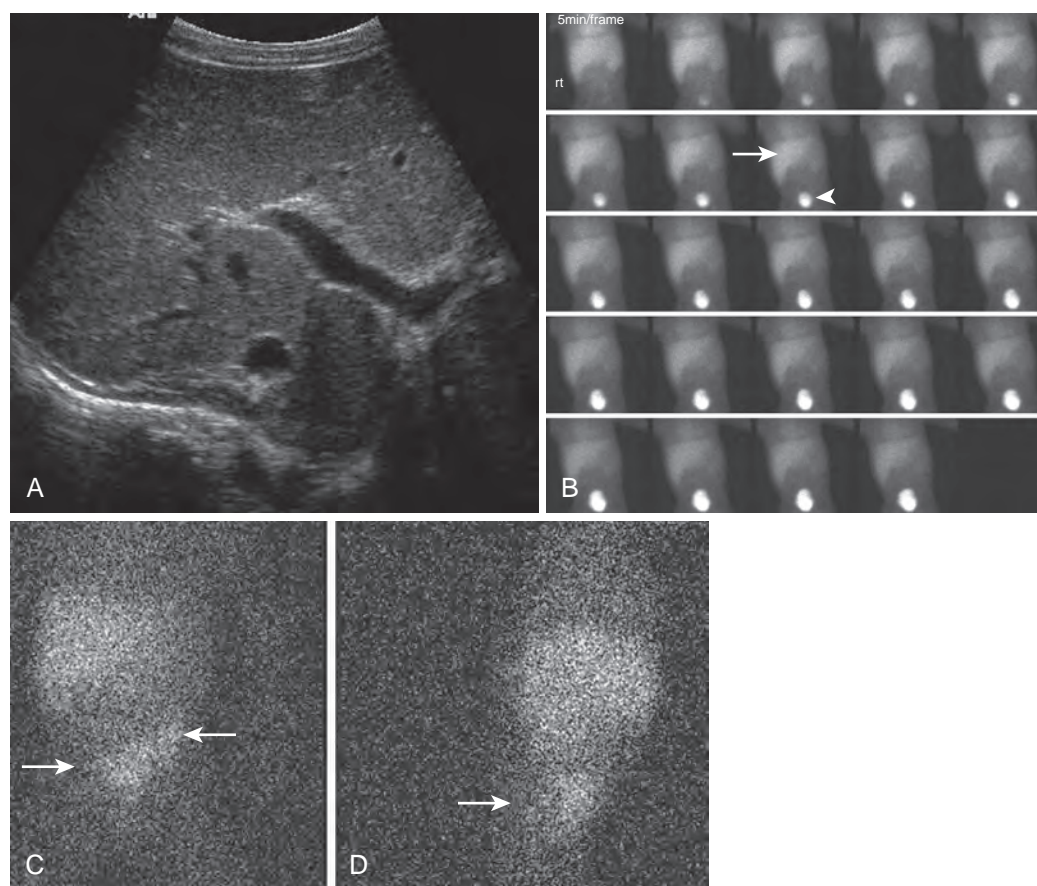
Nonsyndromic intrahepatic bile duct paucity: ultrasound and hepatobiliary scintigram. A. The cholestatic infant has a lack of sonographically identifiable gallbladder or intrahepatic bile ducts. B. Nuclear scintigraphy demonstrates poor hepatic extraction (arrows) of the radiopharmaceutical. Some radiopharmaceutical is seen in the urinary bladder (arrowhead). C and D. There is minimal small bowel activity at 24 hours (arrow). These findings can be seen in the setting of neonatal hepatitis or paucity of intrahepatic bile ducts with cholestasis. Liver biopsy confirmed a paucity of intrahepatic ducts (arrows). This child lacked other clinical abnormalities that are associated with Alagille's syndrome.
